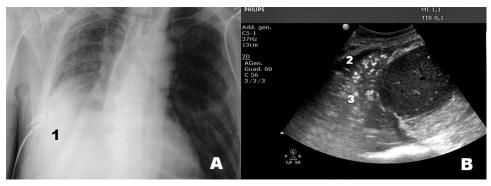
(*A*) Chest radiograph suggested a pleural effusion (1); (*B*) ultrasonography evidenced a small pleural effusion (2) and an important lung consolidation (3).
